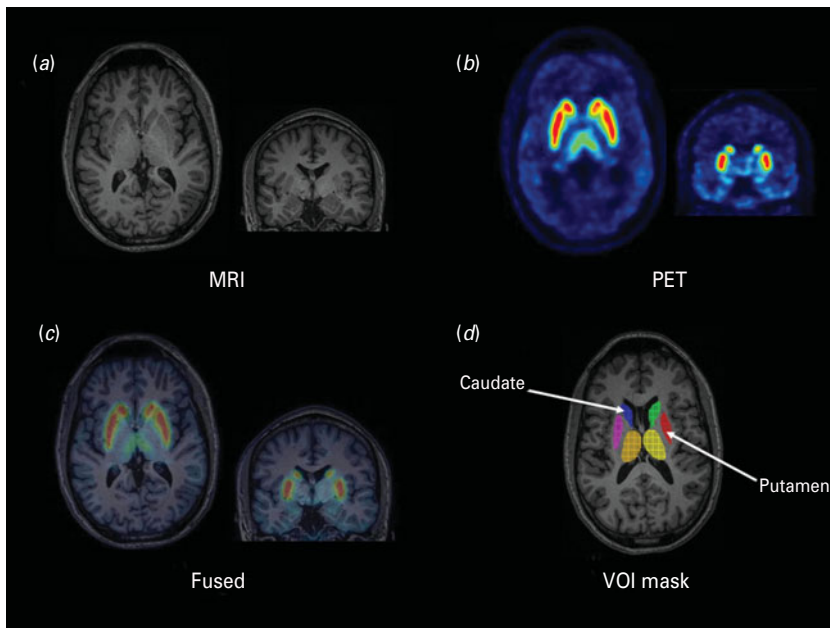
Corresponding magnetic resonance imaging (MRI) and positron emission tomography (PET) scans together with the fused image (co-registered PET to MRI). The volume-of-interest (VOI) mask, created in FSL FIRST, shows caudate and putamen.
